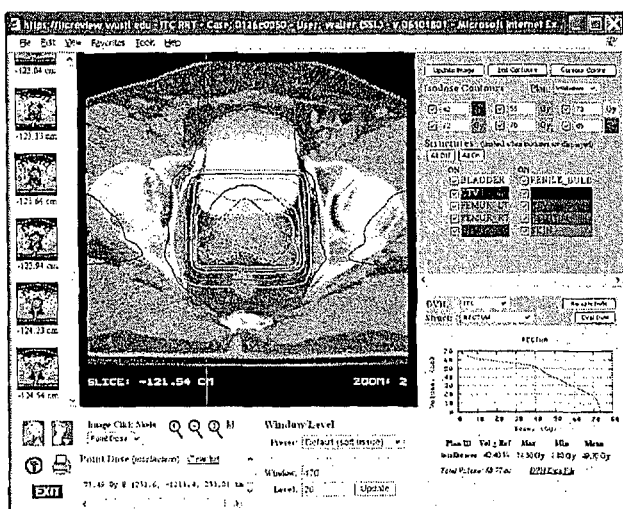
WWW-based Remote Review Tool (RRT) that allows reviewer to review target volume and organs-at-risk contours, and selected isodoses overlaid on axial CT images, and dose-volume histograms, including dose-volume statistics.
